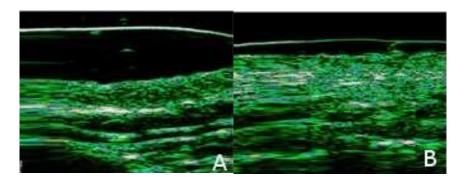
Ultrasound images of dermal thickness increase from baseline (A) to month 7 (B) after treatment with CaHA [29]. (Image courtesy of Yutskovskaya YA and Kogan EA)
